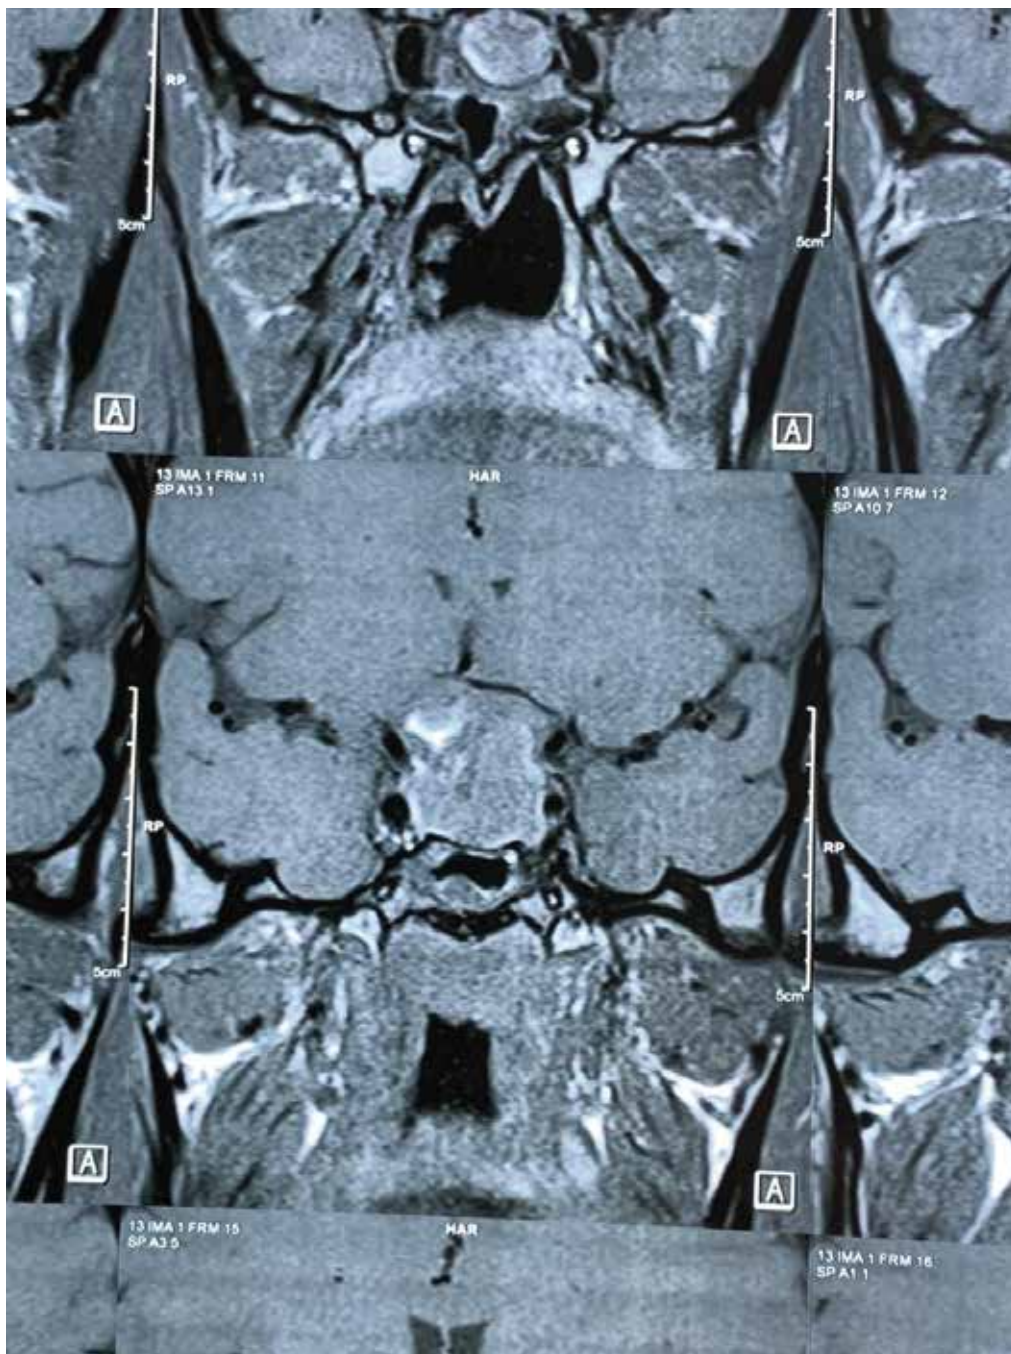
Coronal MRI of Pituitary region showing macro-adenoma with relevant anatomy
